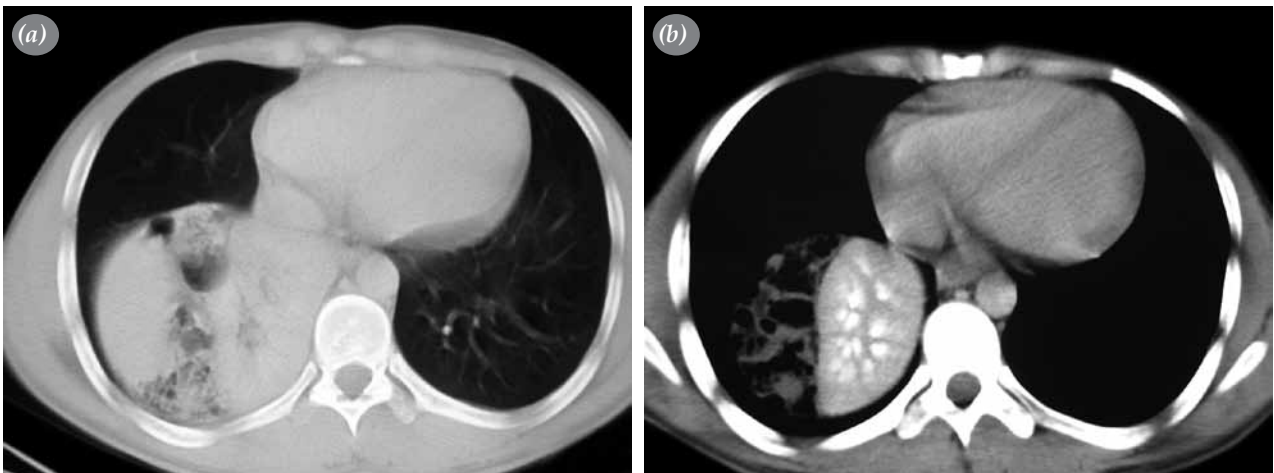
Computed tomography of the patient in (a) paranchimal window, (b) mediastinal window.
